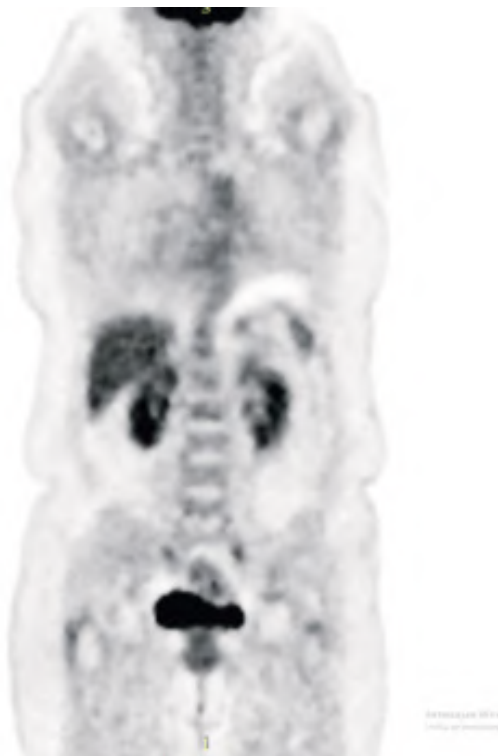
PET/CT scan showing no metabolically active lesions detected.
